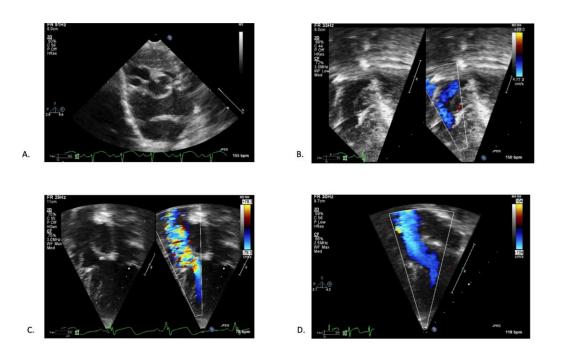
Echo images from a 5-day-old patient with Double Outlet Right Ventricle-Transposition of the Great Arteries type with juxtaposed atrial appendages. (A) Parasternal short axis view - posteriorly there is leftward juxtaposition of the right atrial appendage. (B) Apical 4 chamber view. No left ventricular outflow tract obstruction (LVOTO) noted at this time. (C) Images now at 2 years of age, post-operatively from Arterial Switch Operation. In Apical 4 chamber view, noted is LVOTO secondary to fibromuscular ridge at the crest of the muscular septum with a maximum instantaneous gradient of 75-80mHg with a mean gradient of 35-40mHg. (D) Apical 4 chamber view status post subaortic membrane resection with no residual gradient or turbulent flow seen across the left ventricular outflow tract.
